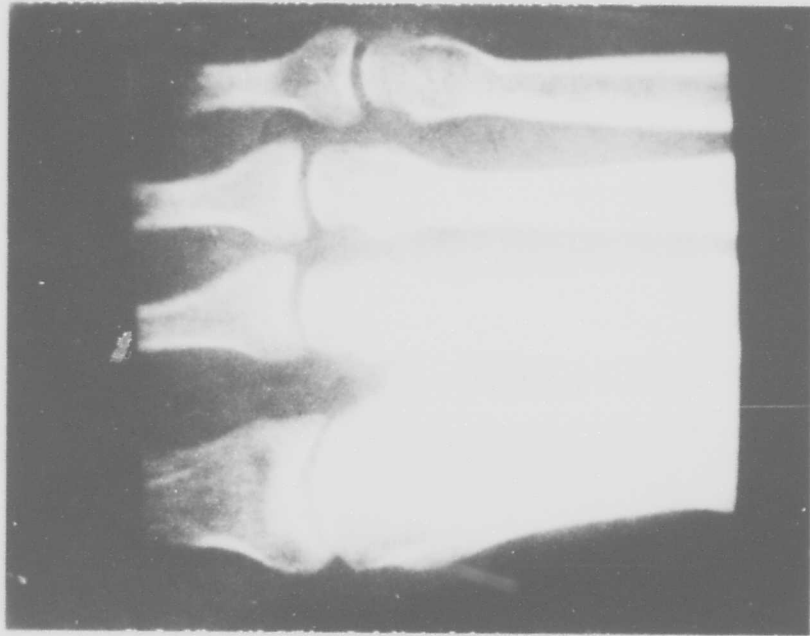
Transmission via land line of x-ray negative of metatarsal bones.
